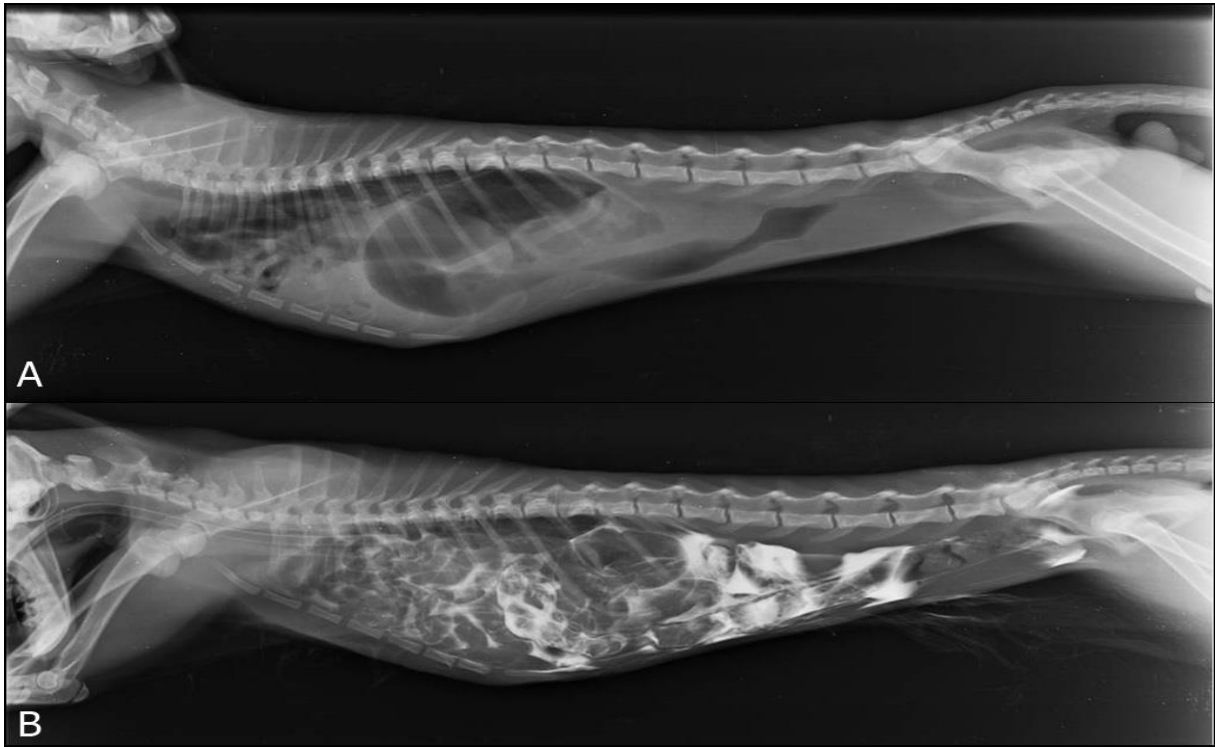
Direct radiography (A) and peritoneography (B).
